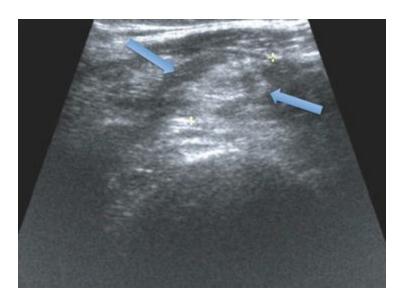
15-year-old-male soccer player 8 days after direct contusion on the thigh. Axial ultrasound shows an ill-defined area of hyperechogenicity (arrows) within the vastus intermedius muscle consistent with contusion
